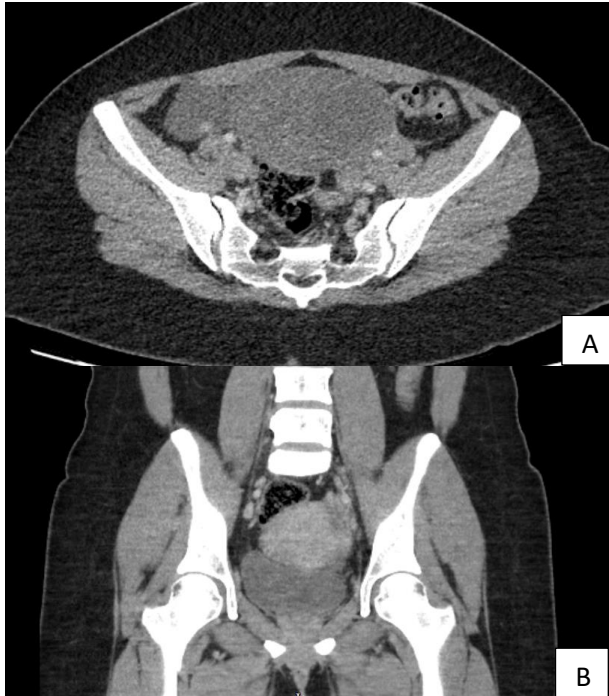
(A and B): CT of our patient showing a 12 cm central pelvis mass.
